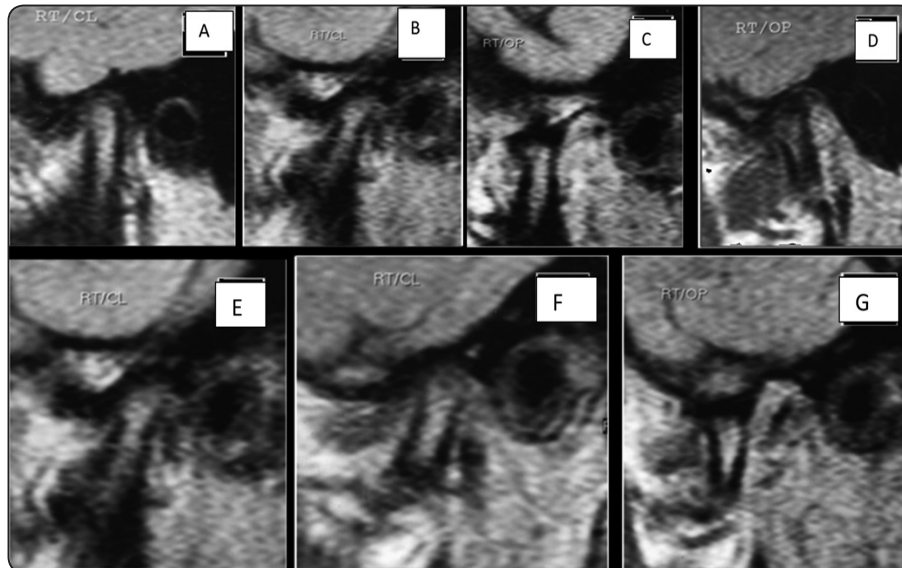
MRI images of sagittal cuts showing normal Rt. Joint. (A and B) pre-operative sagittal cut showing closed disk positions of joint. (C and D pre-operative) sagittal cut showing open joint. (E and F) Postoperative sagittal cuts showing closed joint. (G) Postoperative sagittal cut showing open joint.
